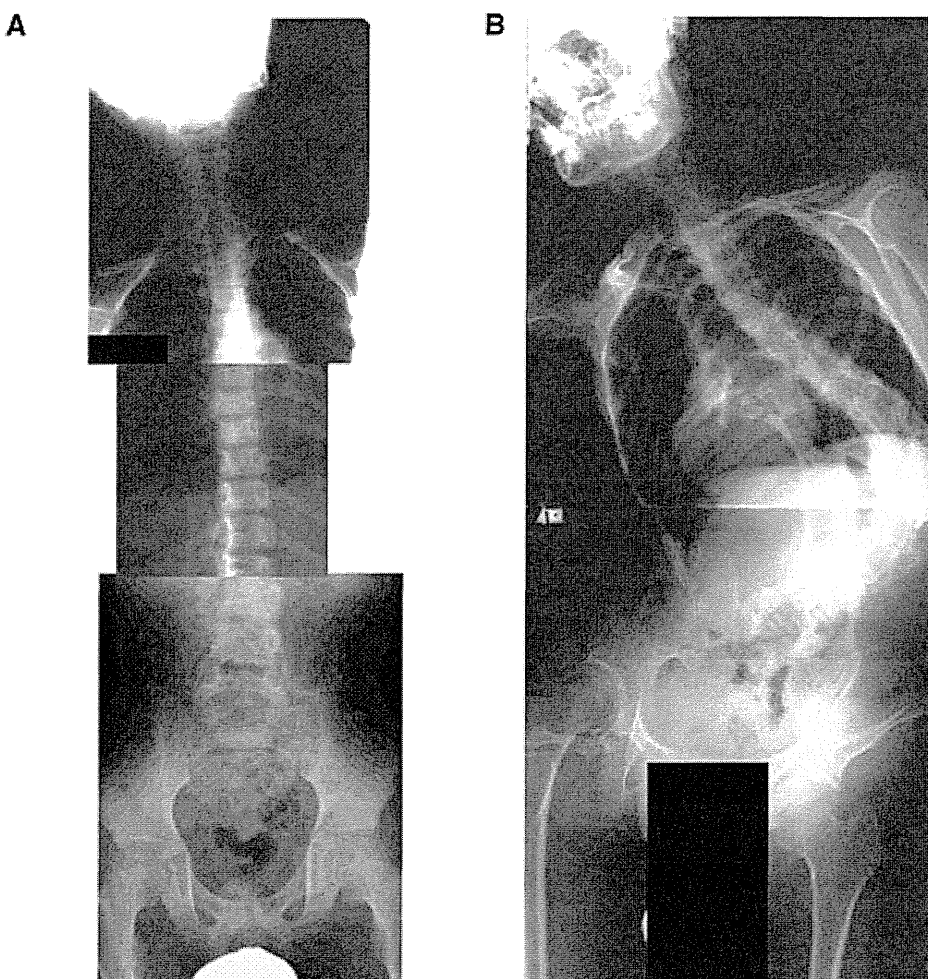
Integrated radiographic films of the vertebral column. (A) At the initial visit (age 8 years, 9 months). (B) At 18 years and 3 months of age, lateral curvature of the vertebral column had become severe.
